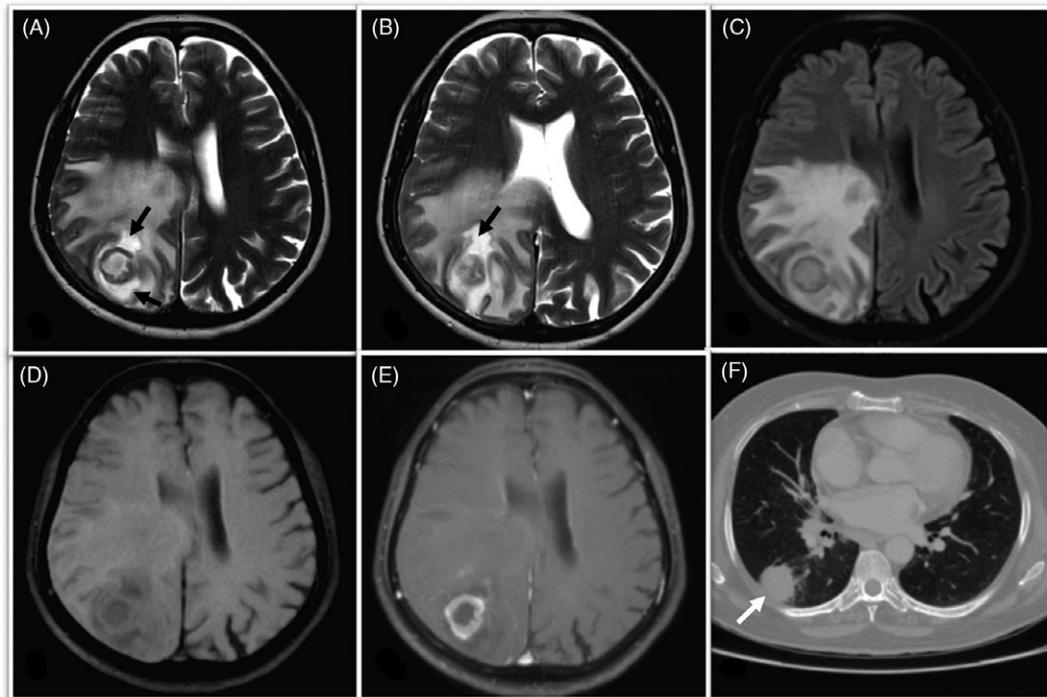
Axial T2-weighted MRI (A, B) shows right parietal lobe lesion with the pool sign (black arrows). The pool of high T2 signal is brighter than the surrounding perilesional vasogenic edema. In FLAIR (C) sequence, the perilesional pooling is not conspicuous and blends with the surrounding edema. The corresponding perilesional rim appears hypointense relative to the gray matter on T1-weighted (D) sequence. Postcontrast T1-weighted MRI (E) shows peripheral enhancement of the lesion. CT scan of the chest (F) shows a right lung mass (white arrow) which was pathology proven adenocarcinoma.
